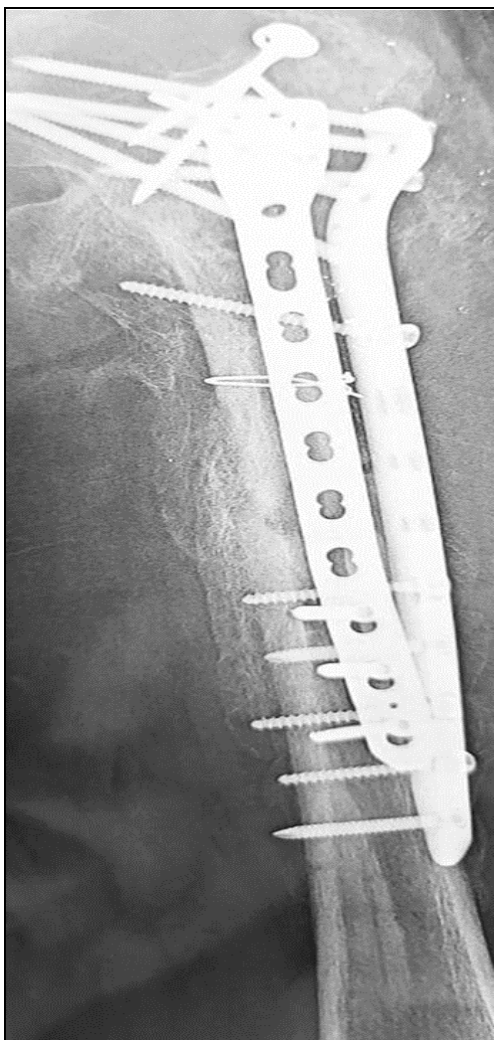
Plan AP x-ray shows signs of callus bridging the fracture posteriorly and medially at three weeks post operation
